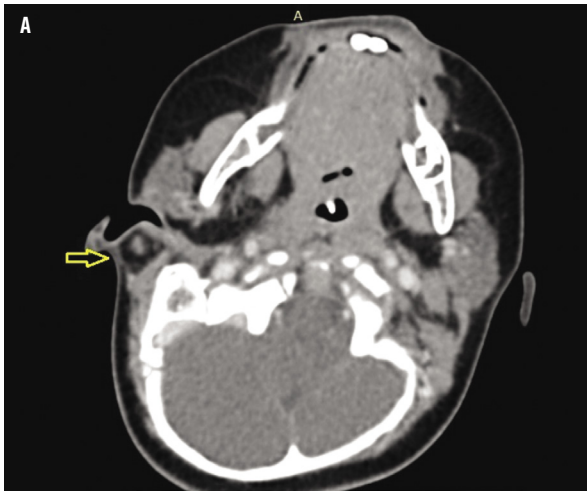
A. Axial contrast-enhanced computed tomography demonstrating a fistulous tract posterior to the right pinna (yellow arrow)
